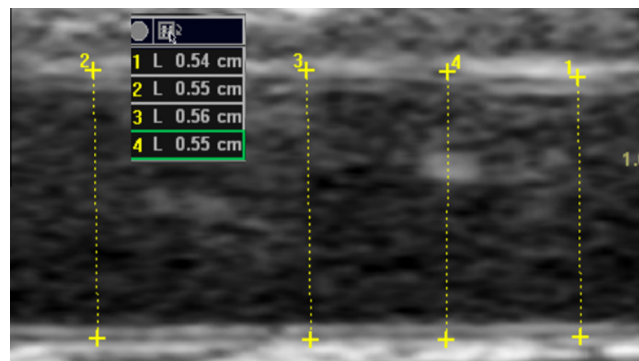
Ultrasonographic measurement of brachial artery diameter.
